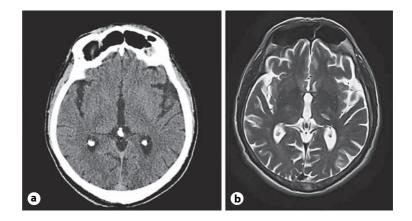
a, b Thalamic lacunae detected on MRI in a patient with negative CT.
